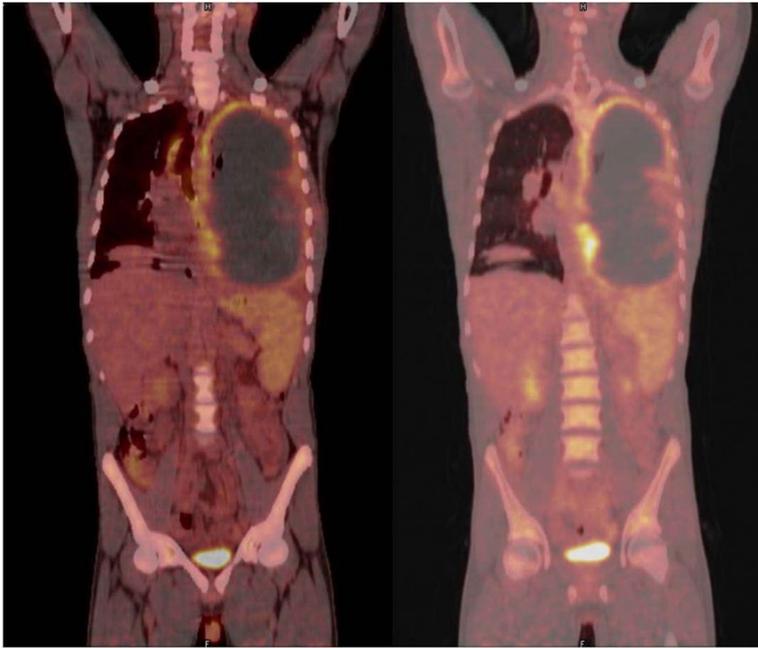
Coronal PET/CT images in soft tissue & lung window showing a large pleural based soft tissue density lesion filling almost the entire left hemithorax with peripheral FDG uptake with central area of hypometabolism and mediastinal shift to right
